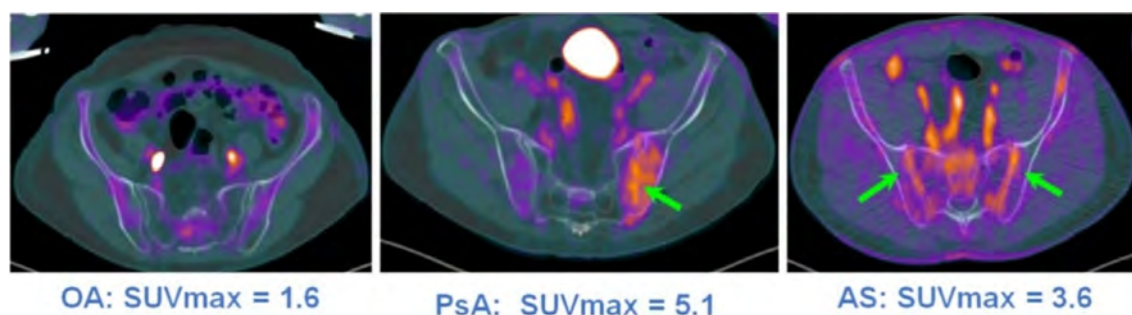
Asymmetric sacroiliac inflammation in Psoriatic arthritis. PET-CT imaging is capable of identifying and providing in vivo quantitative measures of the degree of inflammation (SUVmax) as shown in this figure. Compared to osteoarthritis (OA) marked unilateral SI joint inflammation can be seen in psoriatic arthritis (PsA) and bilateral symmetric inflammation of SI joints in ankylosing spondylitis (AS).
